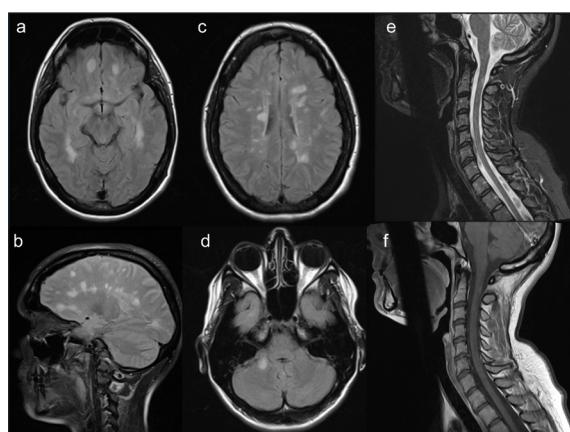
Brain MRI (a-d) showing multiple T2/FLAIR hyperintense lesions: periventricular, subcortical (a,c) and pericallosal (b) as well as in the right middle cerebellar peduncle (d). None contrast enhancing. Spinal cord MRI (e-f) disclosed posterior hyperintense T2/STIR lesion at C2 level (arrow) with discret gadolinium enhancement (*).
